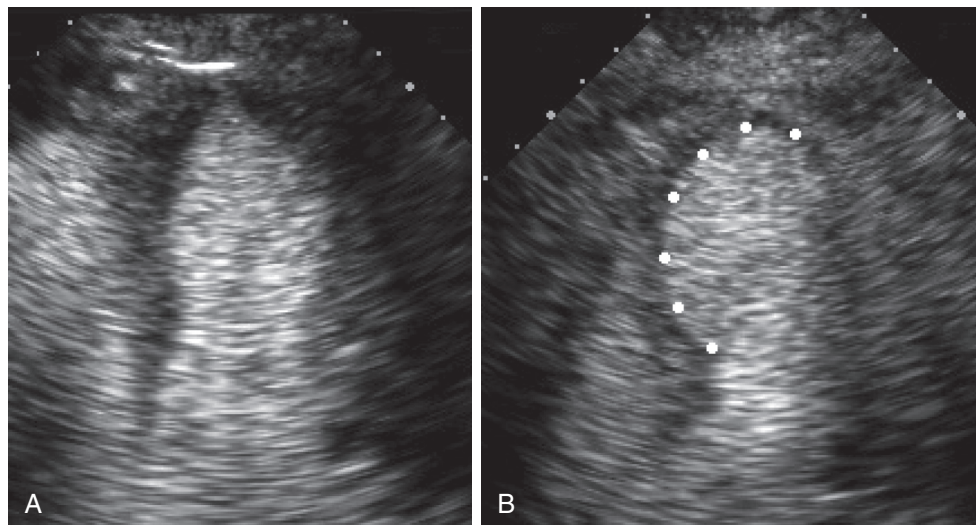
■ Abnormal stress echocardiogram with images of the apical four-chamber view taken at rest (A) and following administration of dobutamine (B). Transpulmonary microbubble contrast is used to opacify the left ventricular chamber. After dobutamine administration, there is a wall motion abnormality, with hypokinesia and contour change in the apex and distal septum of the left ventricle (*dots*).
